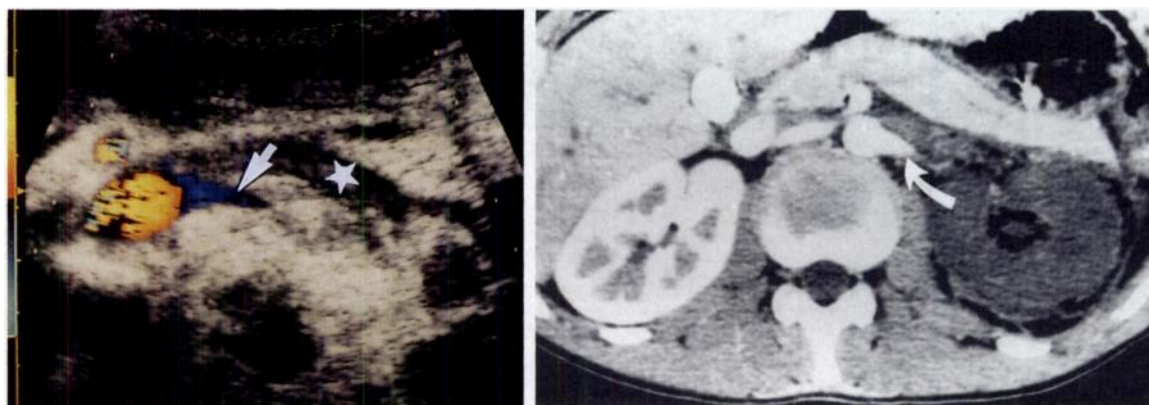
RA occlusion following renal trauma. (a) Color Doppler sonogram shows occlusion of the left RA with an arterial stump (arrow). Note the concomitant RV thrombosis (★). (b) Contrast-enhanced CT scan shows proximal occlusion of the left RA (arrow) and a nonfunctioning, infarcted kidney.
